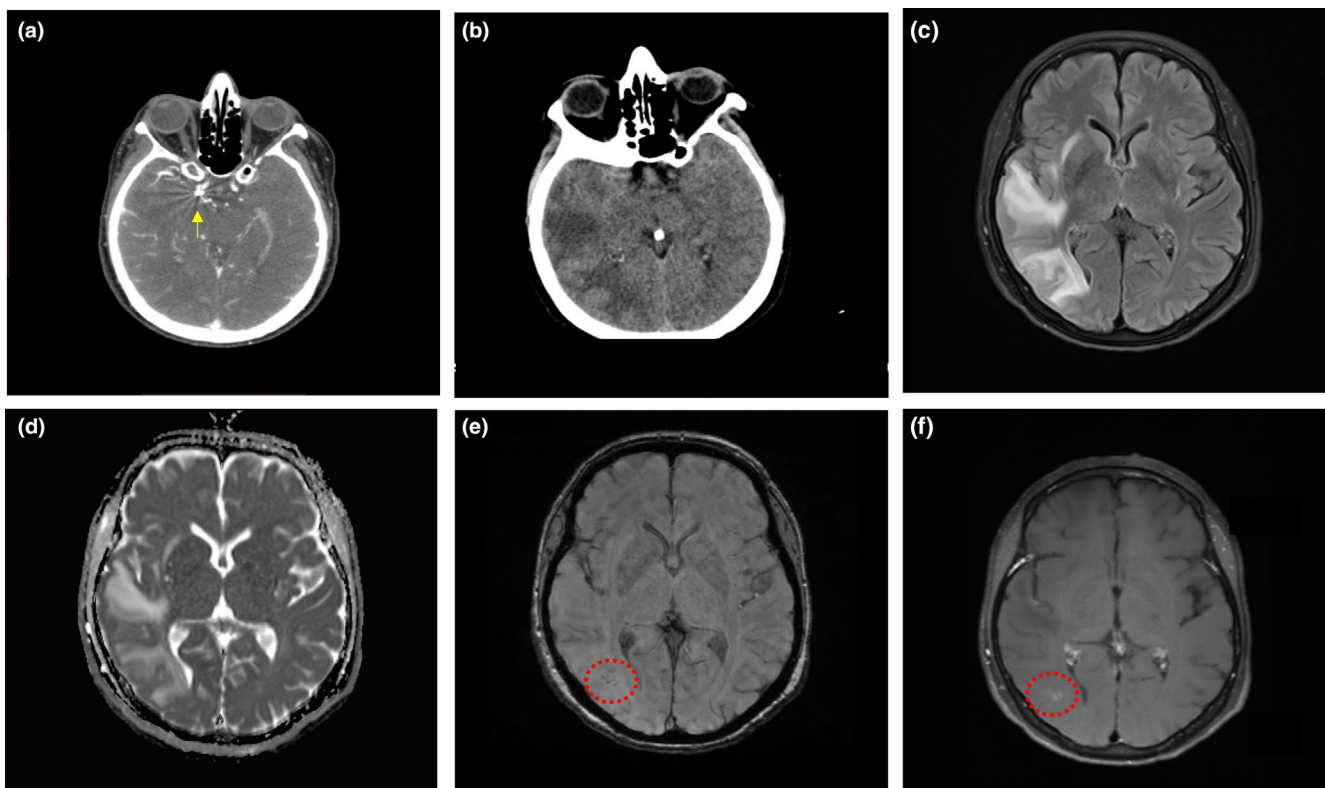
(a) Baseline computed tomography (CT) angiography showing coils in the right posterior communicating artery (arrow). (b) CT of brain demonstrating cerebral vasogenic edema. (c) Axial fluid-attenuated inversion recovery sequence showing diffuse white matter hyperintensities in the right parietal lobe without diffusion restriction on apparent diffusion coefficient maps (d). (e) Axial susceptibility-weighted imaging showing low-signal spots (dotted circle) within the lesions, suggesting the presence of paramagnetic material. (f) Axial T1-weighted image showing slight gadolinium enhancement of the lesions (dotted circle)
